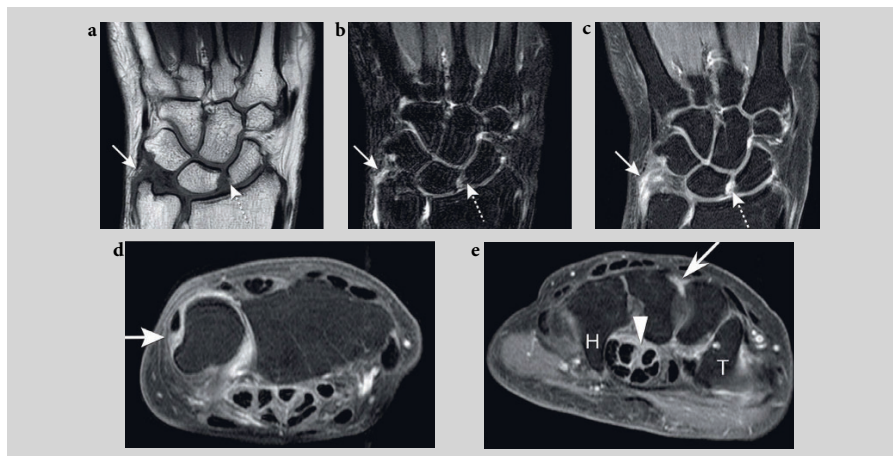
Magnetic resonance images (MRIs) of the left wrist with synovitis in a patient who is positive for anti-citrullinated peptide antibodies with arthralgia but without clinically-detectable arthritis. Coronal T1 TSE (a), T2-TSE fatsat (b) and T1 TSE fatsat with gadolinium, coronal (c), and axial (d) at the level of the distal radial ulnar joint and the carpal tunnel (e). The T2 images show some movement artefacts. Synovial thickening surrounding the distal ulna with irregularity of the triangular fibrocartilage, the signal intensity is intermediate on T1, inhomogeneous increased on T2, showing enhancement after intravenous gadolinium (d, e; arrow). Appreciate the cortical irregularity of the scaphoid and lunate (a, b) with enhancing synovium (c; dotted arrows). The radial styloid shows cortical irregularity as well (a, c). The axial image at the level of the distal carpal tunnel (H, hook of hamate; T, trapezoid) shows enhancement around the flexor tendons (arrow head) and between the capitatum and trapezium, consistent with (teno)synovitis (e; arrow).
